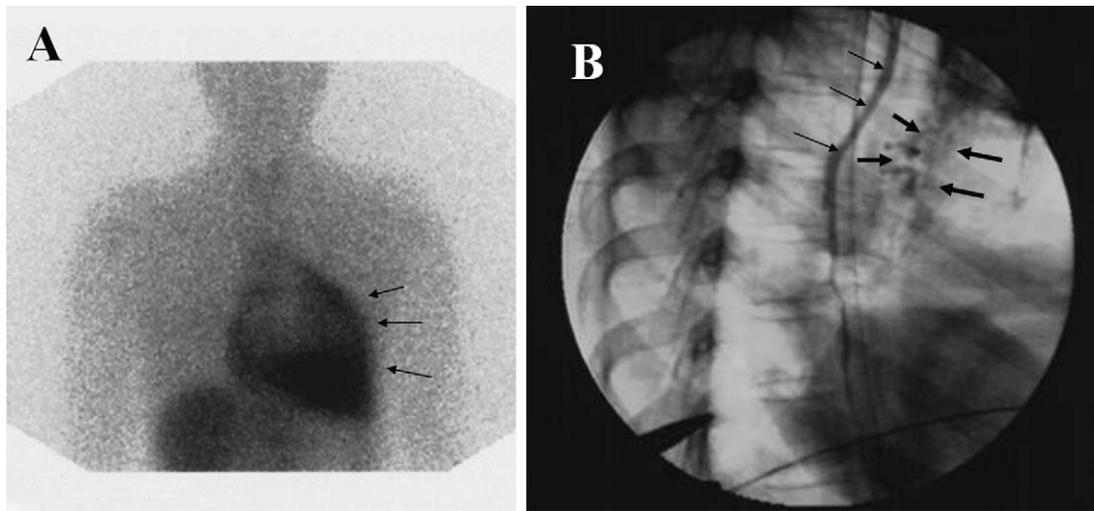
(A) ^{123}I -BMIPP lymphoscintigraphy taken 24 h after oral administration of ^{123}I -BMIPP. Arrows indicate accumulation of ^{123}I -BMIPP in the pericardial sac. (B) Intraoperative thoracic duct angiography shows abnormal reflux of the contrast dye into the pericardium suggesting obstruction of the thoracic duct. Black arrows indicate the thoracic duct and large black arrows indicate abnormal connection into the pericardium.
